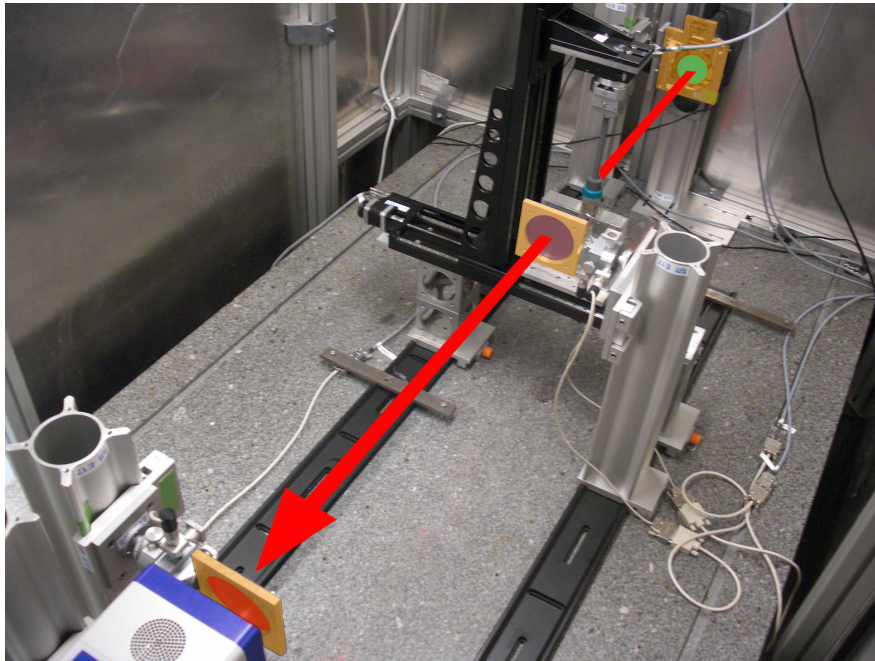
Photograph of the experimental phase-contrast imaging setup. The X-ray source *Enraf Nonius FR 591* is located in the neighboring hutch. The X-ray beam indicated by the red arrow traverses the three colored gratings and then hits the photon-counting detector *PILATUS II 100k*.
